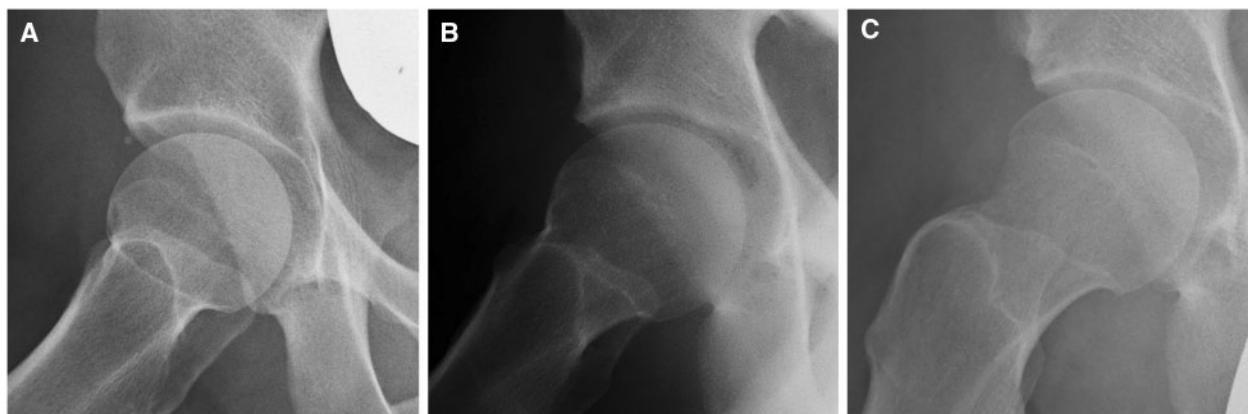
Frog-leg lateral radiographs show the different degree of variation of this phenomenon. In most cases the vacuum sign appears as a narrow stripe leading through the joint cavity like in A, C, D and E. Images F and B represent the smallest (F) and largest (B) recognizable example of the finding.
